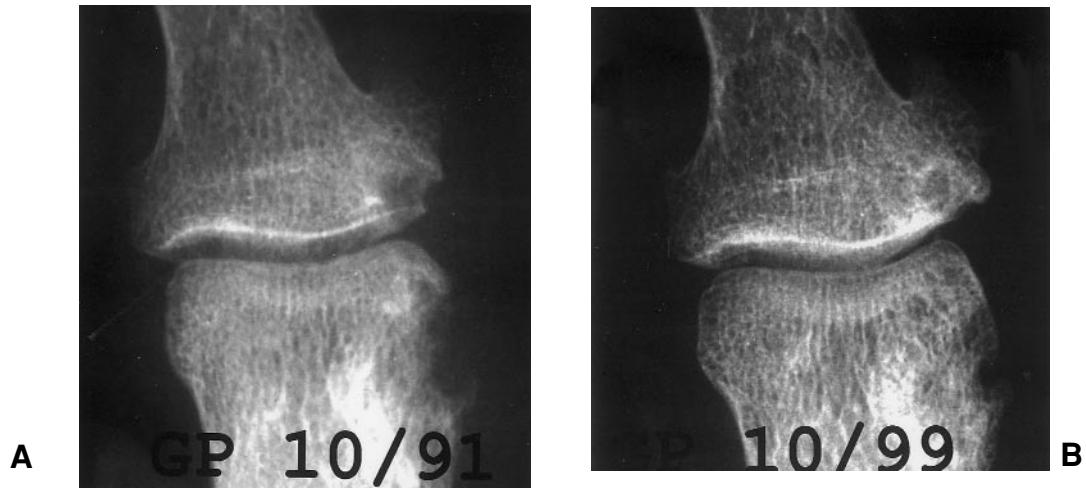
Partial filling in. In October 1991 a radiograph shows active erosions at the proximal and the distal phalanx of the great toe. These erosions are partially (nearly completely) filled in in October 1999.
